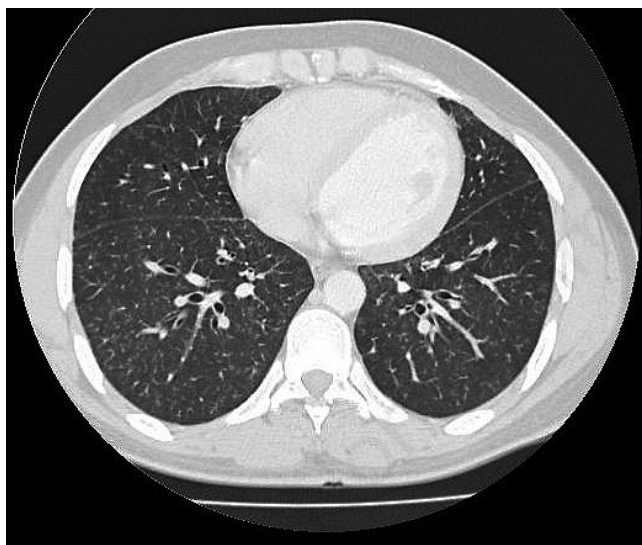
High resolution computed tomography (HRCT) of chest showing bilateral, diffuse, randomly distributed micronodular shadows.
